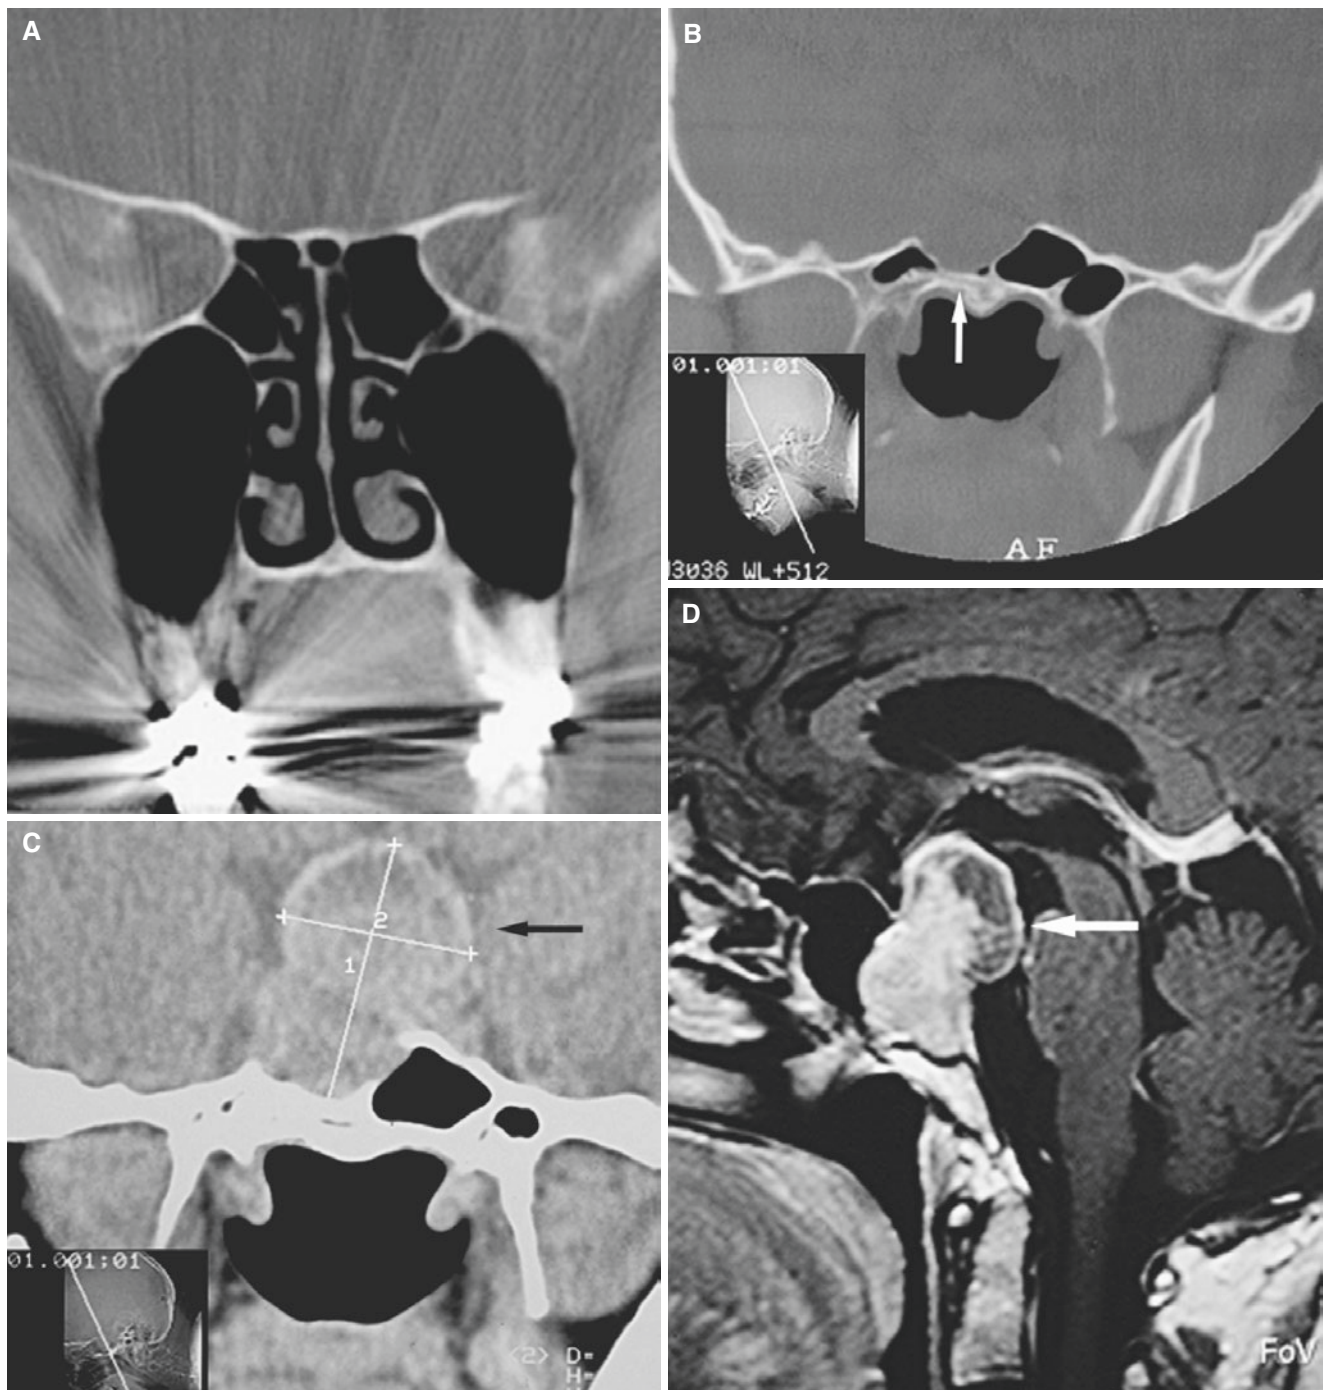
Pituitary adenoma (prolactinoma); 50-year-old female with headache and diffuse facial pain, intracranial tumor detected on routine paranasal sinus scan. (A) Coronal CT of paranasal sinuses, almost all scans normal. (B) Coronal CT, most posterior section shows abnormal
